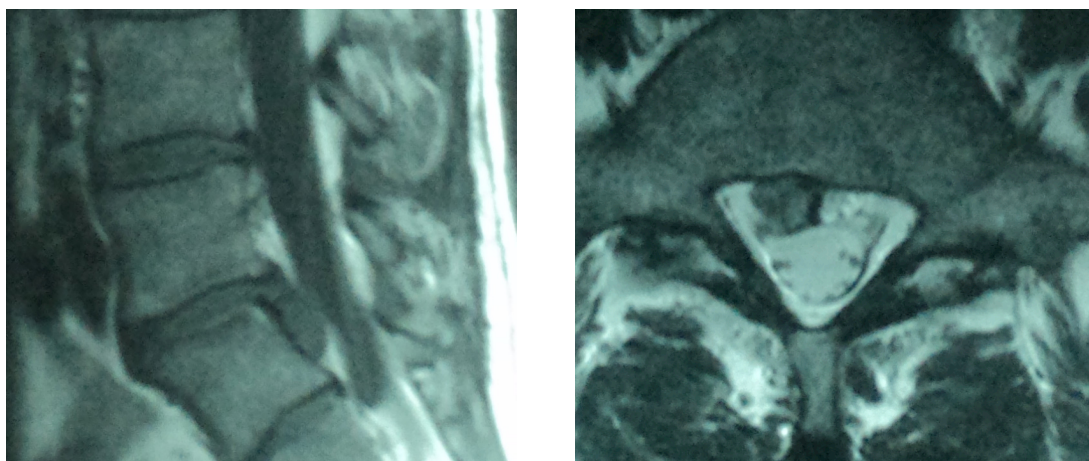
Magnetic Resonance Imaging [MRI] of lumbar spine, four months before operation: Large herniated disc at the level L5/S1 with caudal migration
